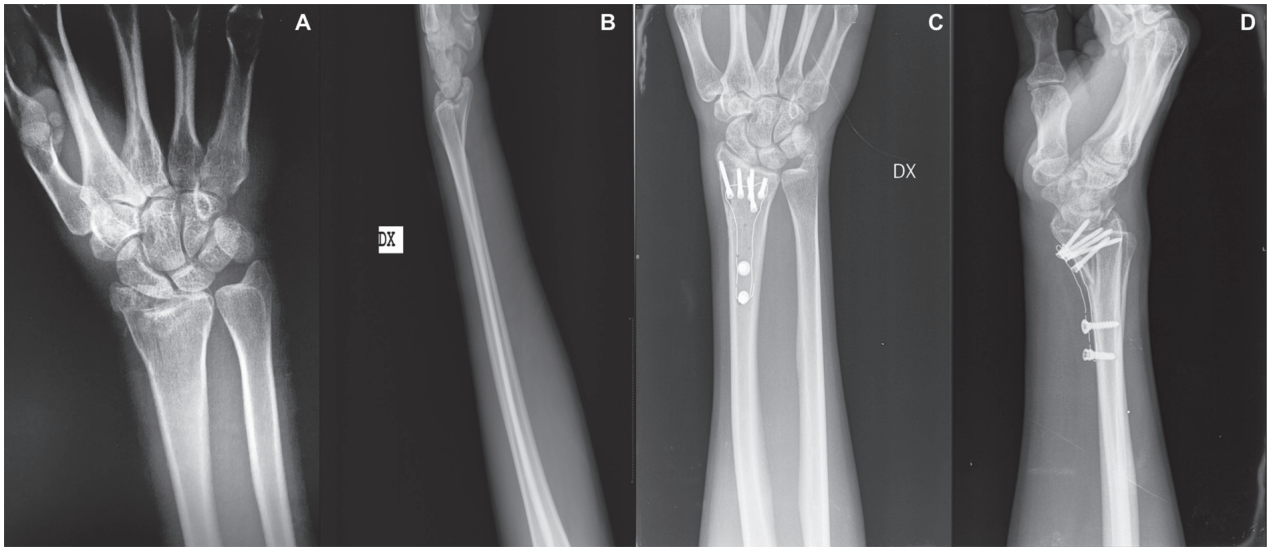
A, B: Pre operative trauma series of a distal radius fracture. C, D: Post operative X-ray of a distal radius fracture treated with a radiolucent triangular plate
